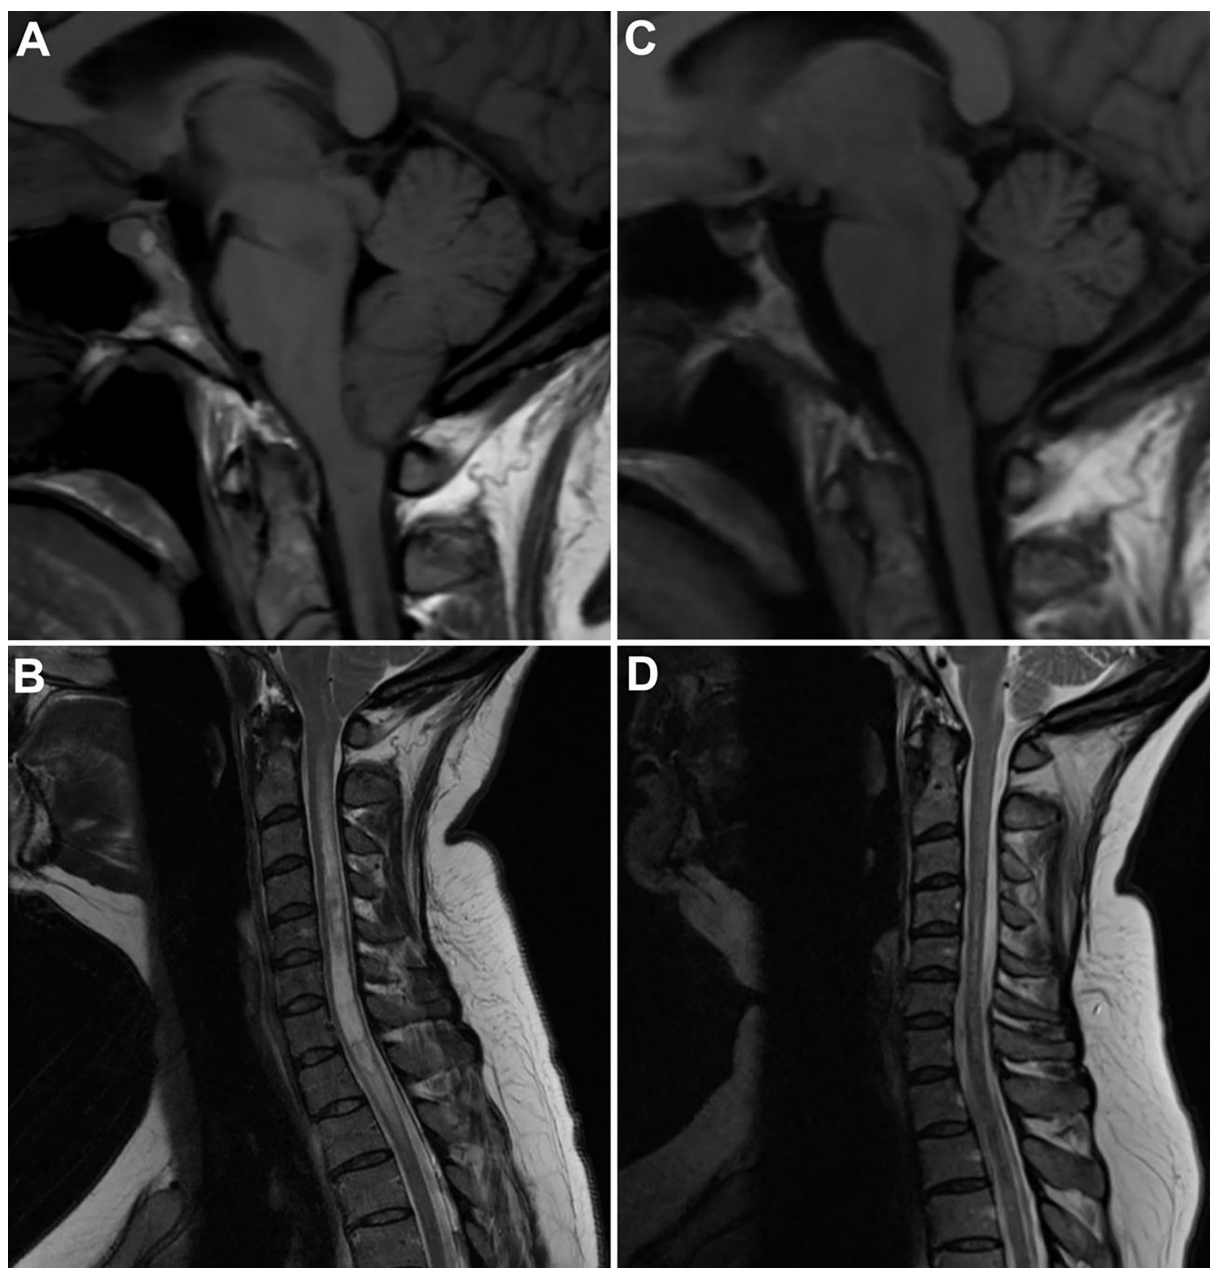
Initial imaging findings of spontaneous intracranial hypotension and cervical syringomyelia. (A) T1-weighted sagittal brain magnetic resonance imaging (MRI) showing cerebellar tonsillar ectopia through the foramen magnum, resulting in the compression of the surrounding cervicomedullary space. There is also enlargement of the pituitary gland and engorgement of the straight sinus. (B) T2-weighted sagittal cervical spine MRI showing an expansile, loculated syrinx in the cervicothoracic region. (C) T1-weighted sagittal brain MRI demonstrating complete resolution of the tonsillar ectopia, brainstem compression, pituitary enlargement, and venous engorgement. (D) T2-weighted sagittal cervical spine MRI demonstrating near-complete resolution of the syrinx.
